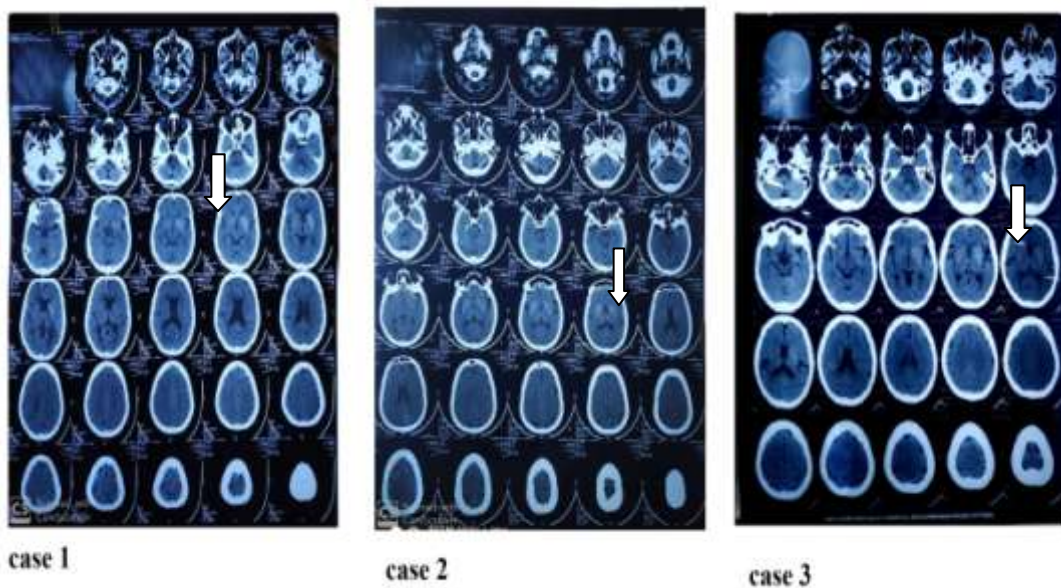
showing the CT findings in case 1 - with left putamen>caudate, right caudate; case 2 - bilateral caudate and putamen; case 3 - left caudate and putamen showing the abnormalities
